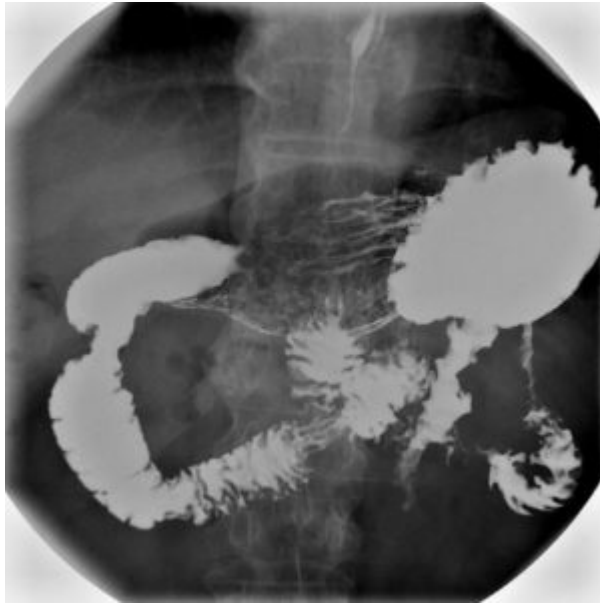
"X-ray of the stomach with both positive (bariumsulphate) and negative (CO2)contrastmedia" by Lucien Monfils. License: [CC BY-SA 3.0](#)
